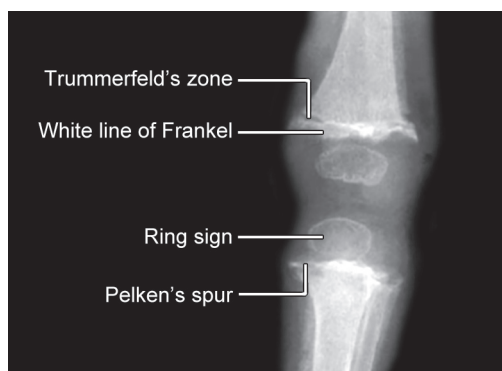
X-ray: Scurvy (knee)
